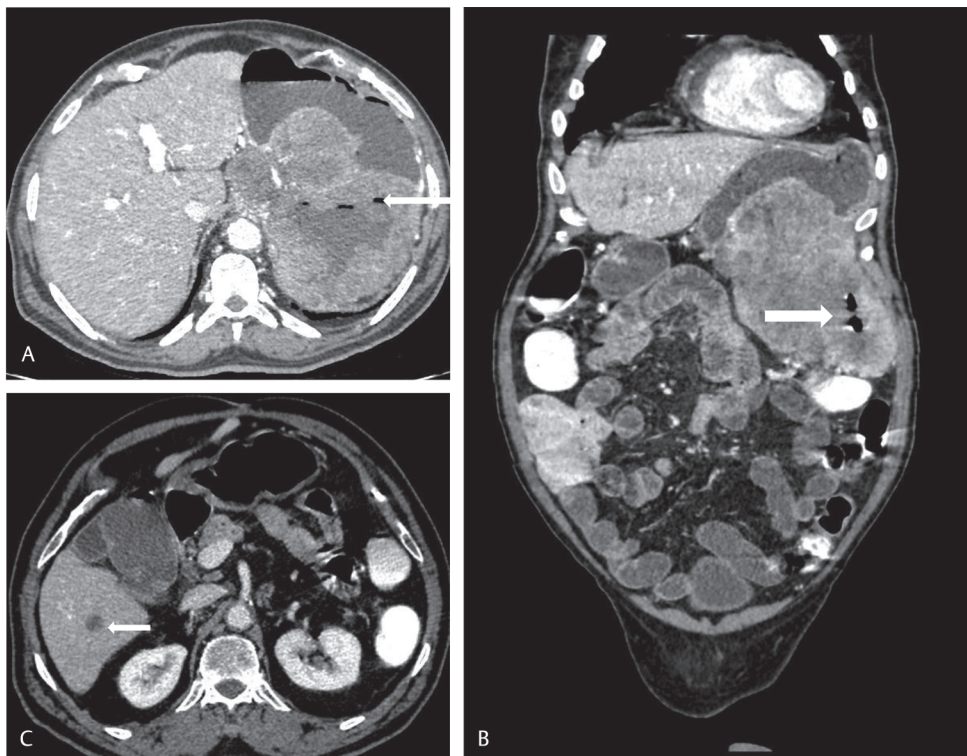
(A) Axial and (B) coronal reformatted contrast-enhanced CT images of a large gastric gastrointestinal stromal tumor (GIST) showing endo-exophytic growth pattern and associated fistulous communication with gastric lumen. White arrows point to air pockets within the central necrotic portion of tumor. Tumor had $> 30\%$ necrosis. High risk. Mitotic index (MI) $> 5/50\text{ HPF}$. Size 16.2cm. (C) Axial CECT taken 6 months after surgery shows cystic metastasis within central necrotic portion of tumor which confirms fistulous communication in right lobe of liver (white arrow).
